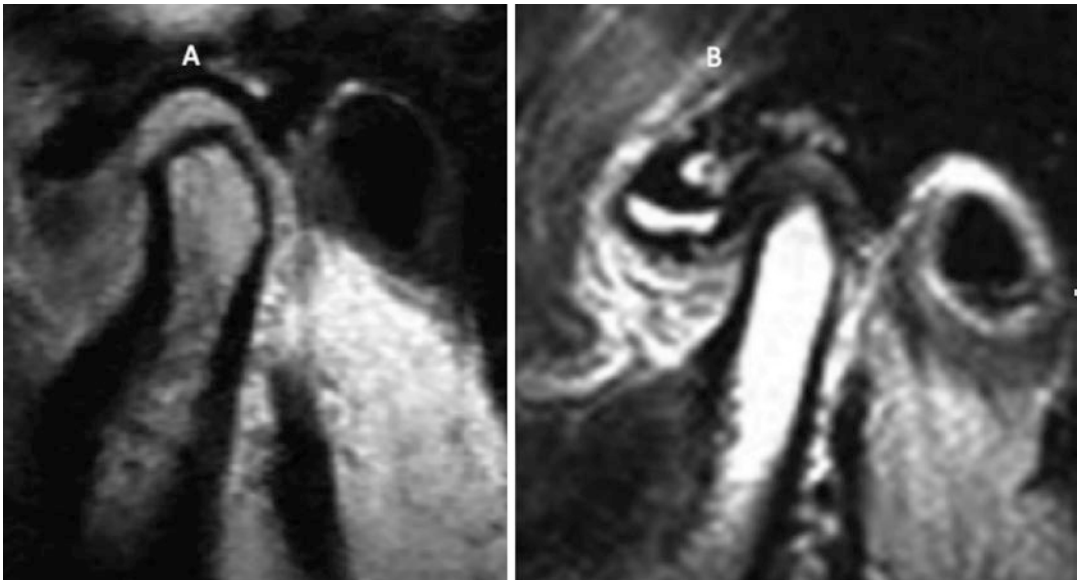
(a) Example T1-weighted image sagittal view of TMJ in a closed mouth position with anterior disk position. (b) T2-weighted sagittal view of the TMJ in a closed mouth position with an effusion of the superior disk space. (Image courtesy of Dr. Robert Reti)
